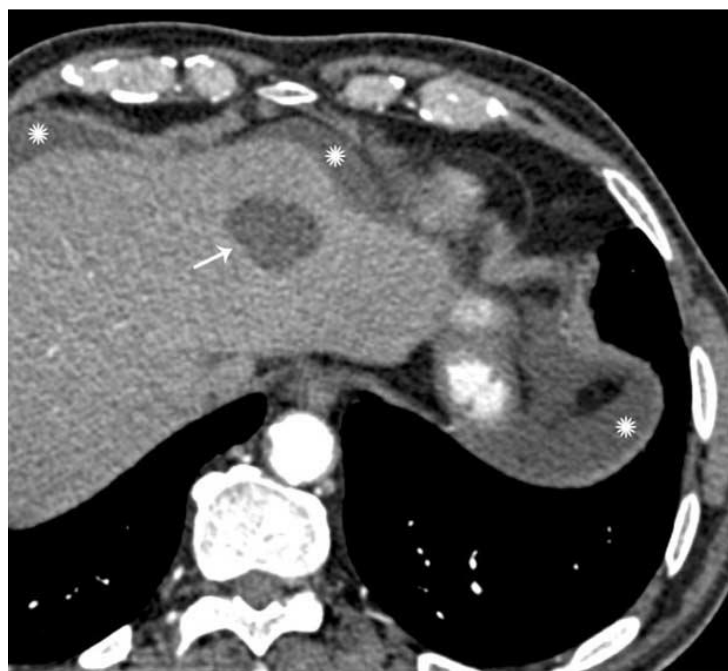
Liver cyst (arrow) and ascites (asterisk) incidentally detected in 71-year-old man who was referred for coronary CT angiography for congestive heart failure.
